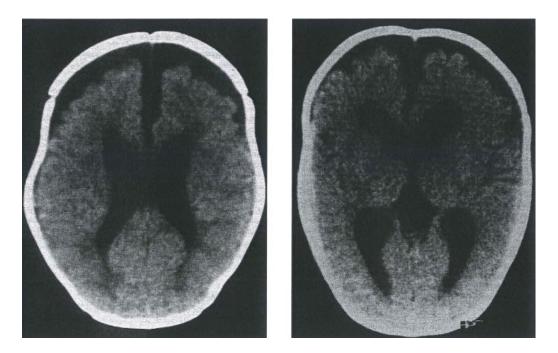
shows two images from CT scans taken when the patients were 5 months old (left, Case 1) and 6 months old (right, Case 2). These scans reveal that the brain ventricles are moderately enlarged, and there is also evidence of fluid collecting outside the brain.
